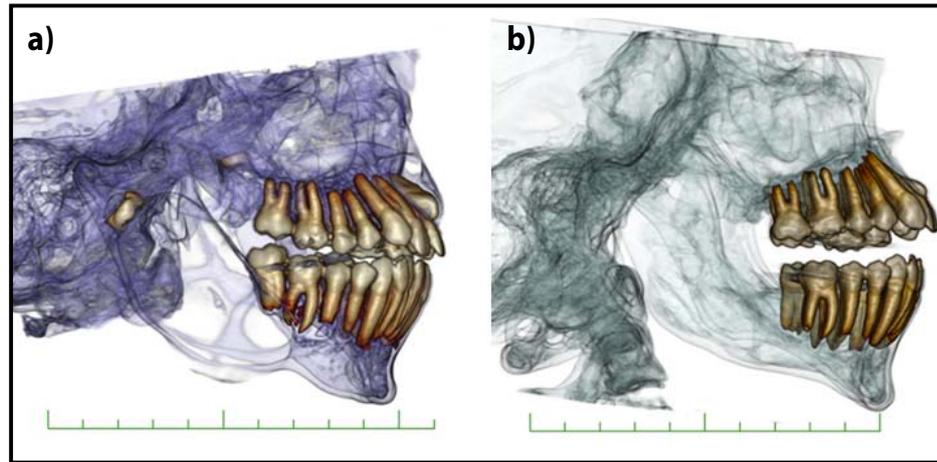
a) A CT scan (3D reconstruction) before surgery: cyst on the right ramus of the mandible with resorption of both lateral and medial compact bone; retained tooth 23, surrounded by a cystic lesion; resorption of the right tuber of the maxilla caused by the cyst in that location; b) CT 3D reconstruction 1 year after treatment.
